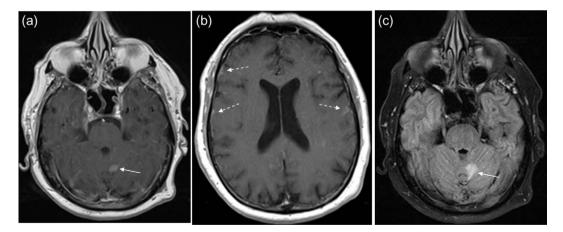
Leptomeningeal infiltration (cerebral). Nodular contrast enhancement medially in the left cerebellum (arrow) and diffuse contrast enhancement on the cerebral surface (stippled arrows) on contrast enhanced axial T1-weighted images (a, b) with corresponding high signal intensity in cerebellum (arrow) on axial FLAIR image (c) in the patient with leptomeningeal PCL.
